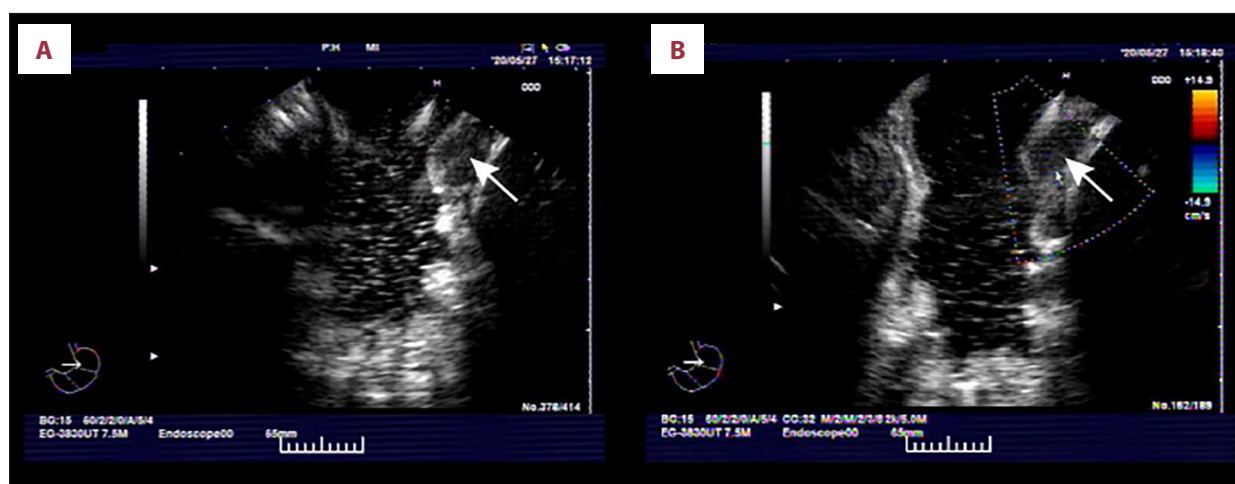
(A, B) Endoscopic ultrasonography shows a 2.0×0.8 cm, well-defined, hypoechoic mass arising from the muscular layer in stomach wall.
